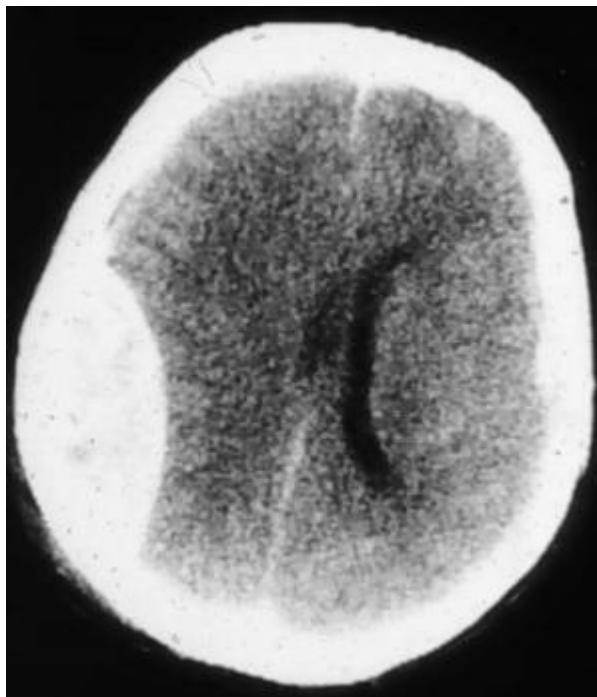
CT appearance of epidural haematoma
